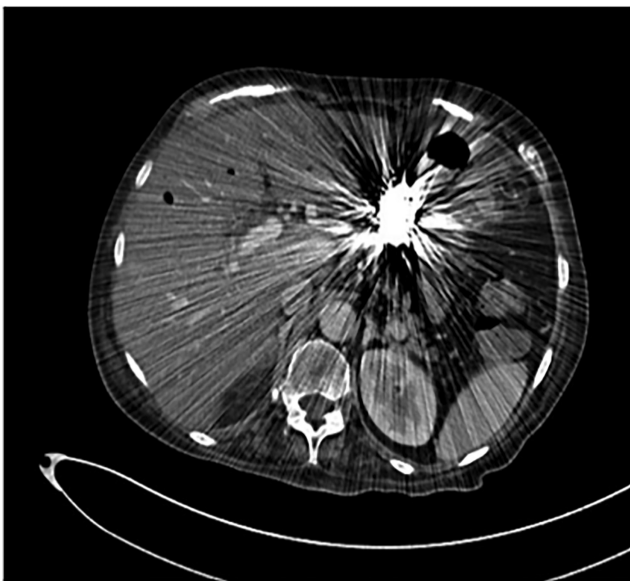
Control CT scan. The CT scan showed no signs of vascularization within the treated PSA and absence of active bleeding.
